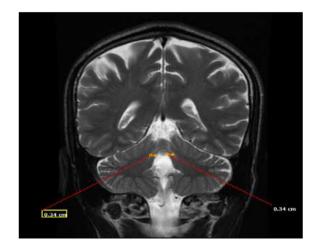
T2-weighted coronal MRI image showing measurements of the right and left superior cerebellar peduncle (SCP) width.
